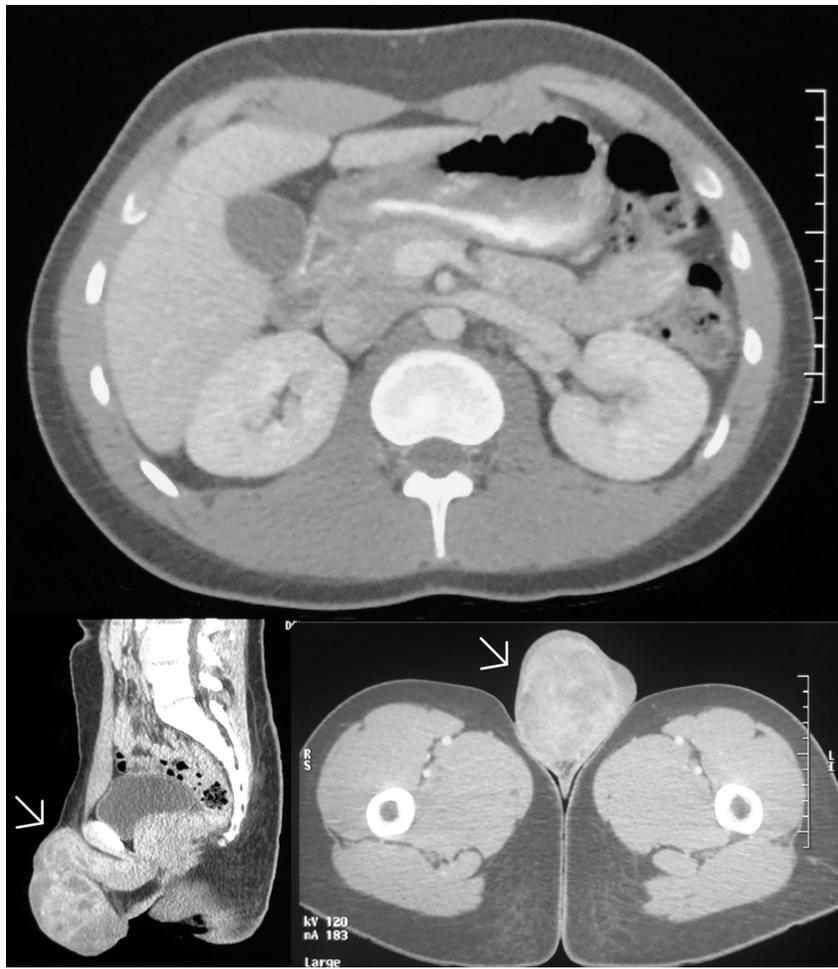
Preoperative radiological workup. Abdominopelvic CT scan with IV contrast shows the presence of an enhancing, 8 cm x 6.7 cm mass in the right testicle, as indicated by the white arrows. No evidence of retroperitoneal adenopathy is identified.
